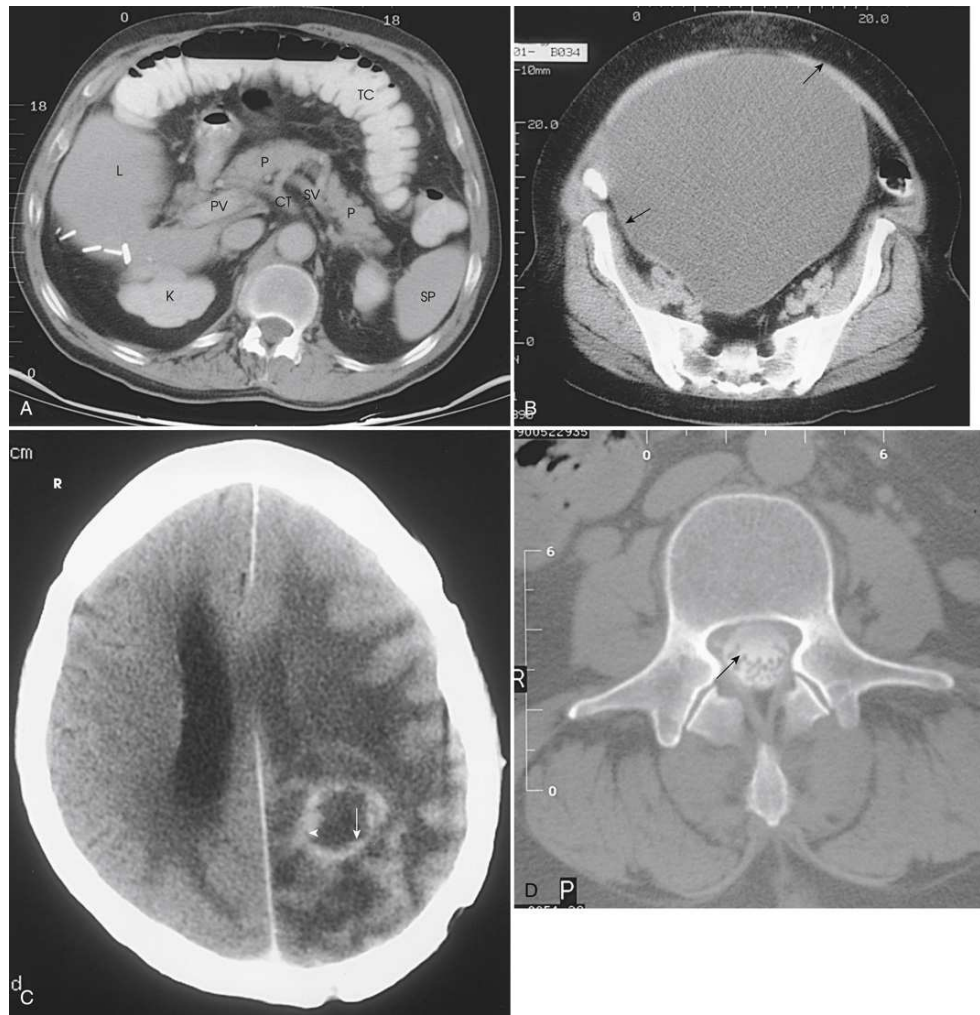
(A) Abdominal image showing transverse colon (*TC*) with air-fluid levels; liver (*L*), pancreas (*P*), spleen (*SP*), kidney (*K*), portal vein (*PV*), celiac trunk (*CT*), and splenic veins (*SV*) are shown with contrast medium. Surgical clips are seen in posterior liver. (B) Abdominal image showing extremely large ovarian cyst (*arrows*). (C) Brain image showing parietooccipital mass (*arrow*) with characteristic IV contrast ring enhancement (*arrowhead*). (D) Image of L3 after myelography showing contrast material in thecal sac (*arrow*).
